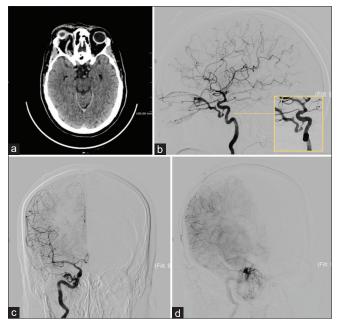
In (a) preoperative brain computed tomography scan shows significantly dilated right superior ophthalmic vein (SOV) and right exophthalmos, compared to the left side. Angiographic captures (lateral projection in [b], posterior-anterior projection in [c], and oblique projection in (d) show a right indirect carotid cavernous fistula (Barrow type "B"). In the yellow box in (b) the enlargement of the fistula documents the fistulous site filled by a single arterial trunk coming from the inferolateral part of the intracavernous right internal carotid artery and draining into the ipsilateral SOV, conditioning clinical congestion of the right eye, and multiple congested facial and maxillary veins. It should be noted intense SOV opacification during arterial pass of iodate contrast medium.
